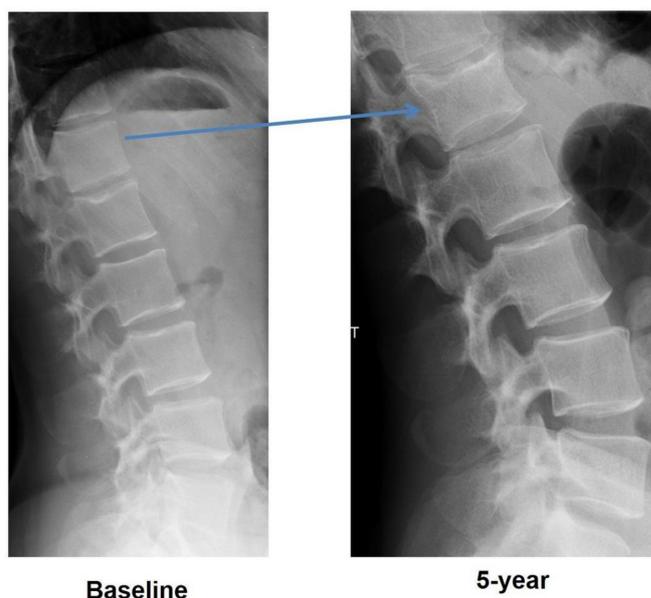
Incident vertebral fracture on spine radiographs.
